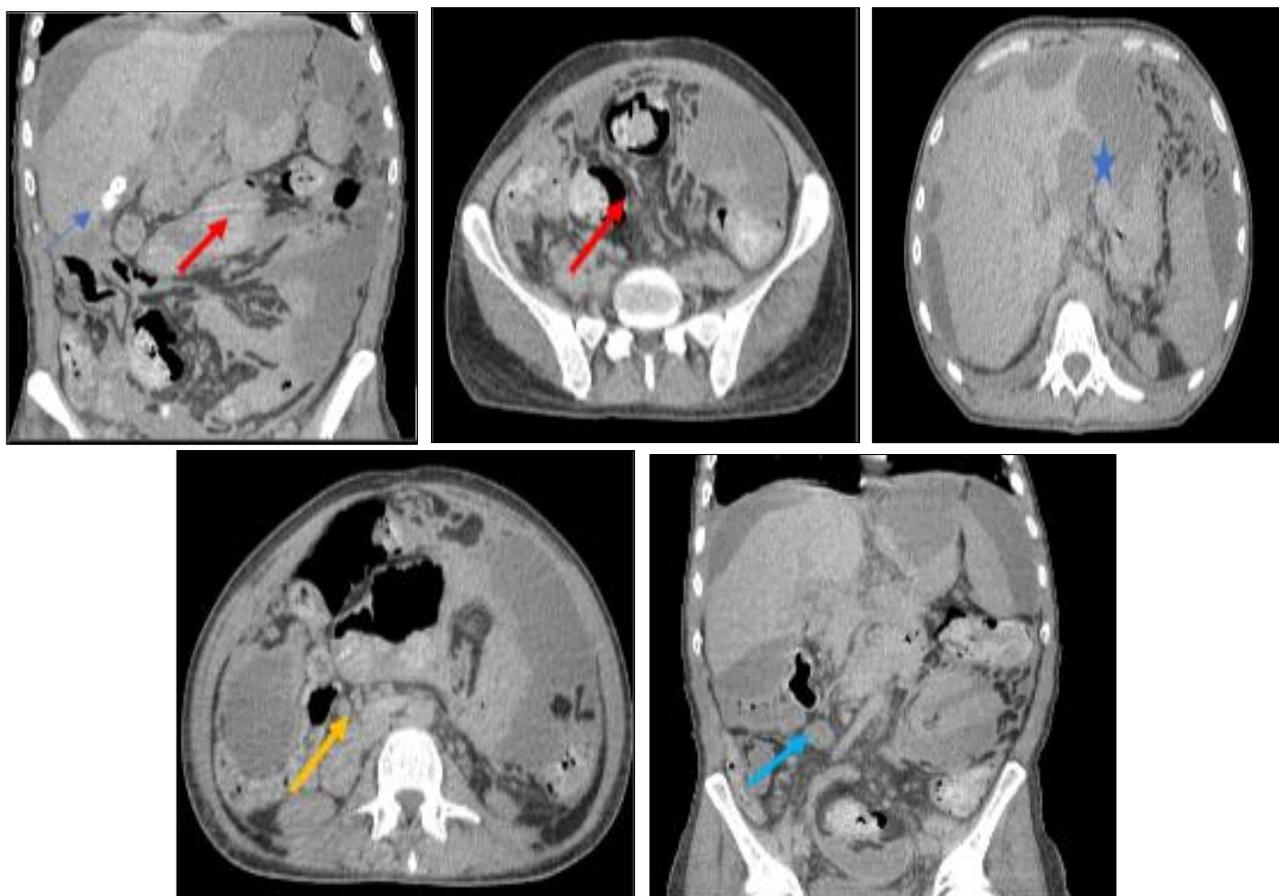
Abdominal CT scan with PDC injection objective:
